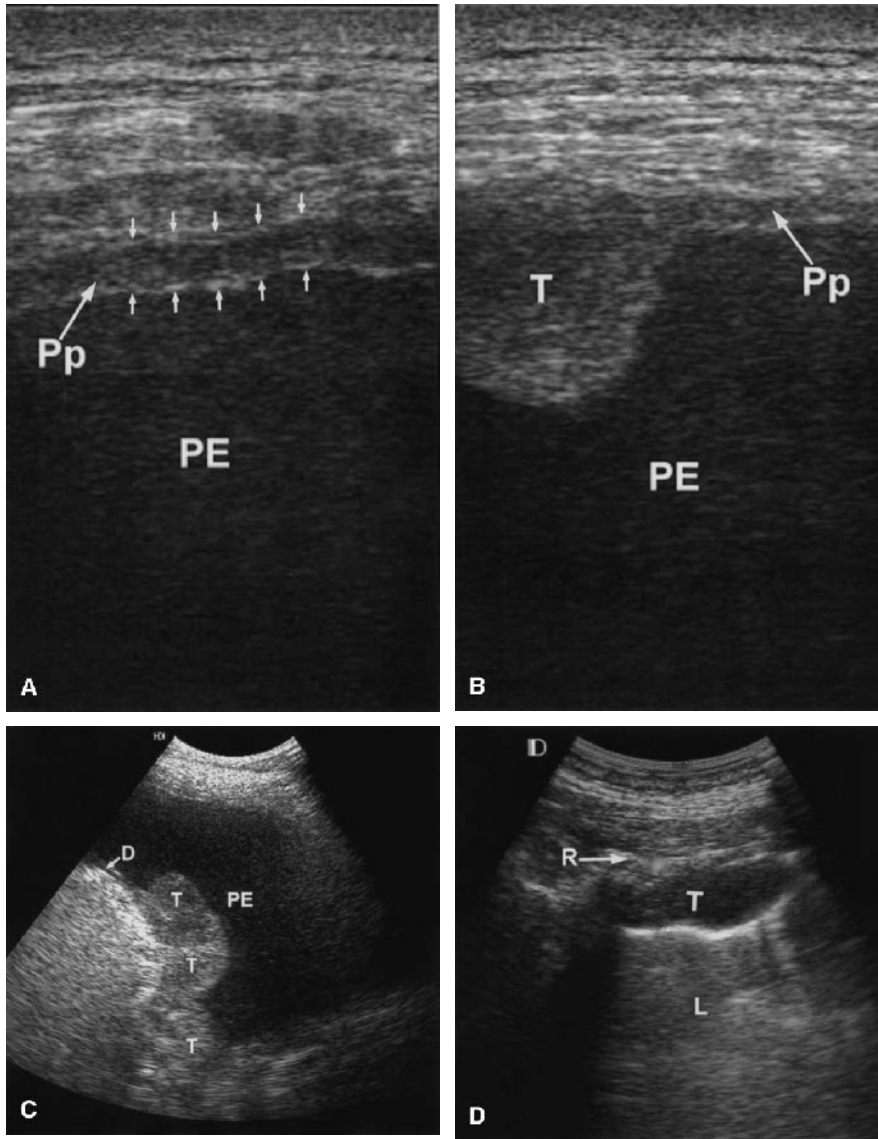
Ultrasound (US) images of pleural thickening and pleural tumors
